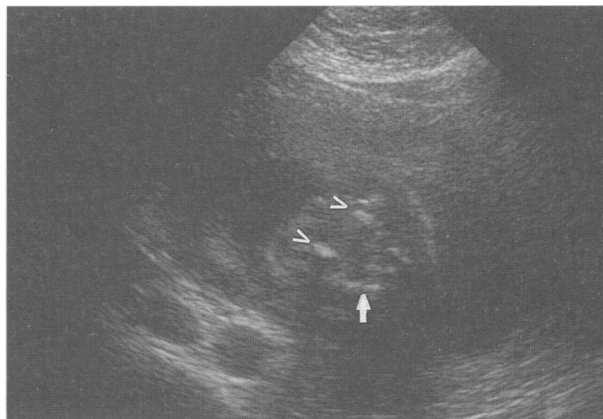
The sonogram shows a fetus undergoing muscle biopsy. The closed arrow points to needle in a fetal buttock. The open arrows point to ischial tuberosities.
